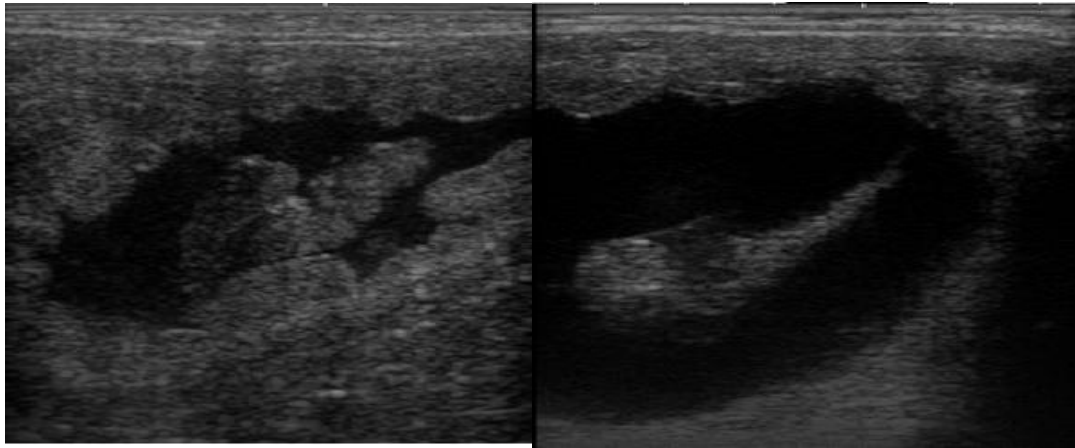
Ultrasound Image Depicting
